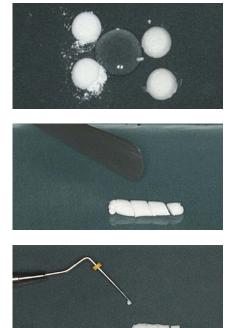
Obturation paste manipulated with calcium hydroxide, 2% chlorhexidine gel and zinc oxide in the proportion of 2:1:2. Radiographic exam after insertion of obturation paste.
